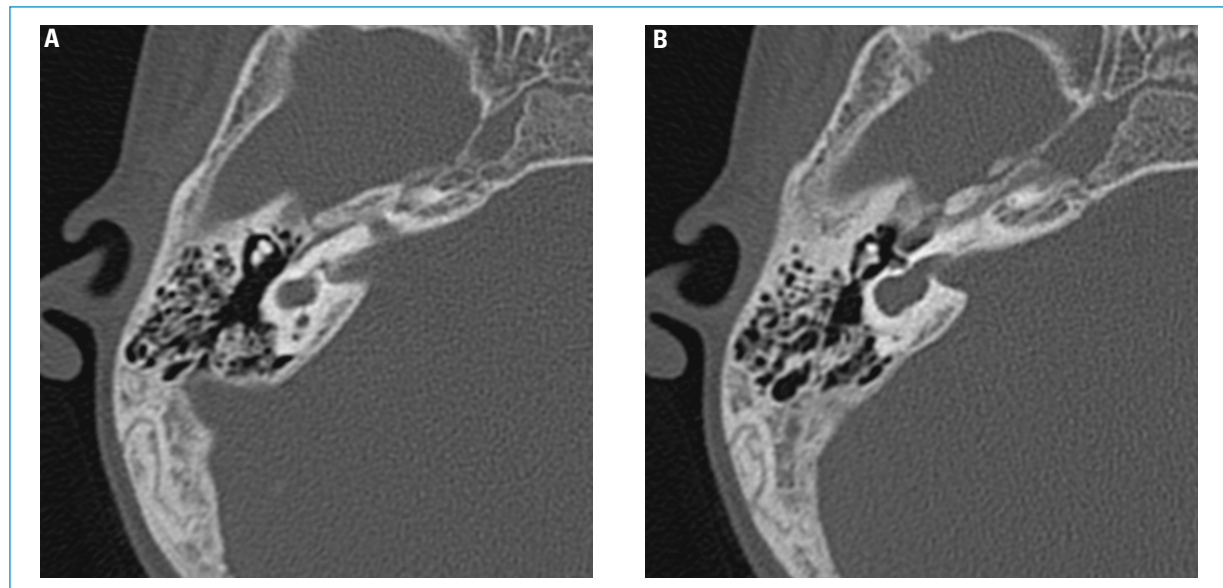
A and B: CT scan (axial) of the right temporal bone showing a common cavity malformation involving an abnormal cochlear partition and communication between the subarachnoid space and perilymph.
